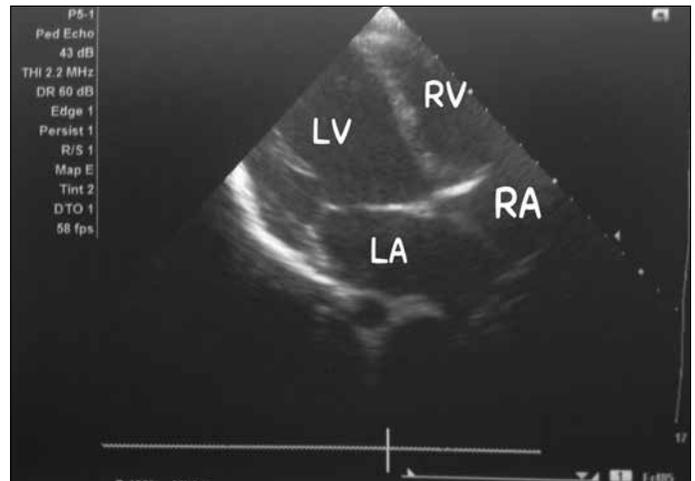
Two-dimensional echocardiogram showing a four-chamber view of the heart in a patient with systolic dysfunction. Note: dilated LV
